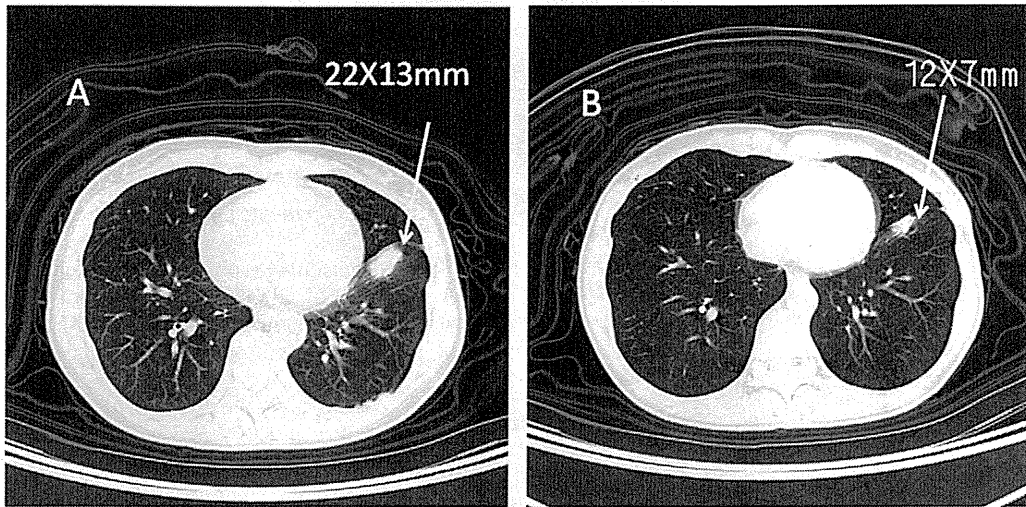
CT scan (Case 2): A, 07/22/2009 (before ALK inhibitor) and B, 09/02/2009 (5 weeks after the initiation of the therapy). Left S8 tumor (arrow) decreased in size from 22X13 mm to 12X7 mm (PR).
